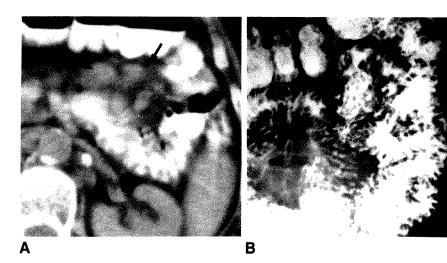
Lymphoma diffusely infiltrating small bowel with extensive nodular fold thickening. Changes are apparent on both CT (A) and barium (B) evaluations. Mesenteric (arrows) and paraaortic lymphadenopathy is seen on CT.
